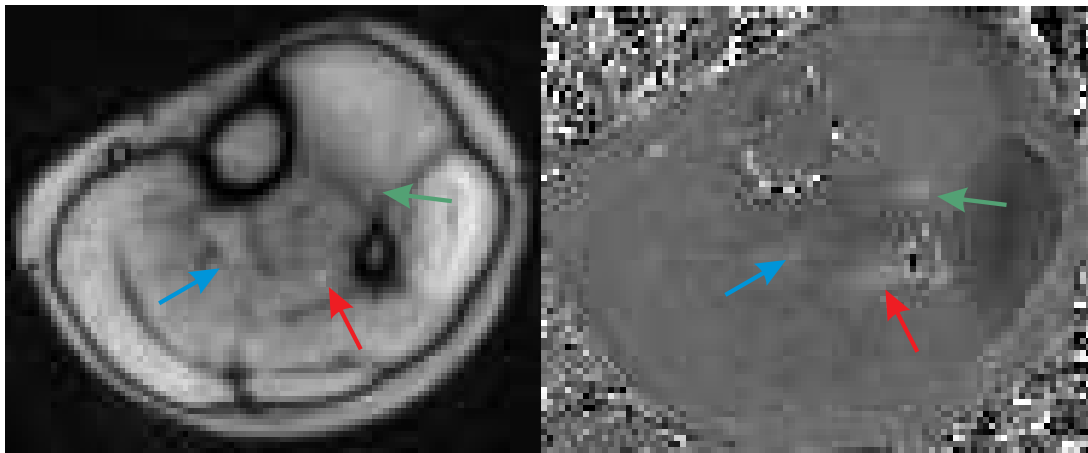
Magnitude image (left) and phase-contrast map (right) of peripheral venous flow obtained from lower limbs at the region of the calf muscles using real-time PC MRI during flexion and extension of the foot. Region of interests include anterior tibial vein (blue), fibular vein (red) and posterior tibial vein (green).
